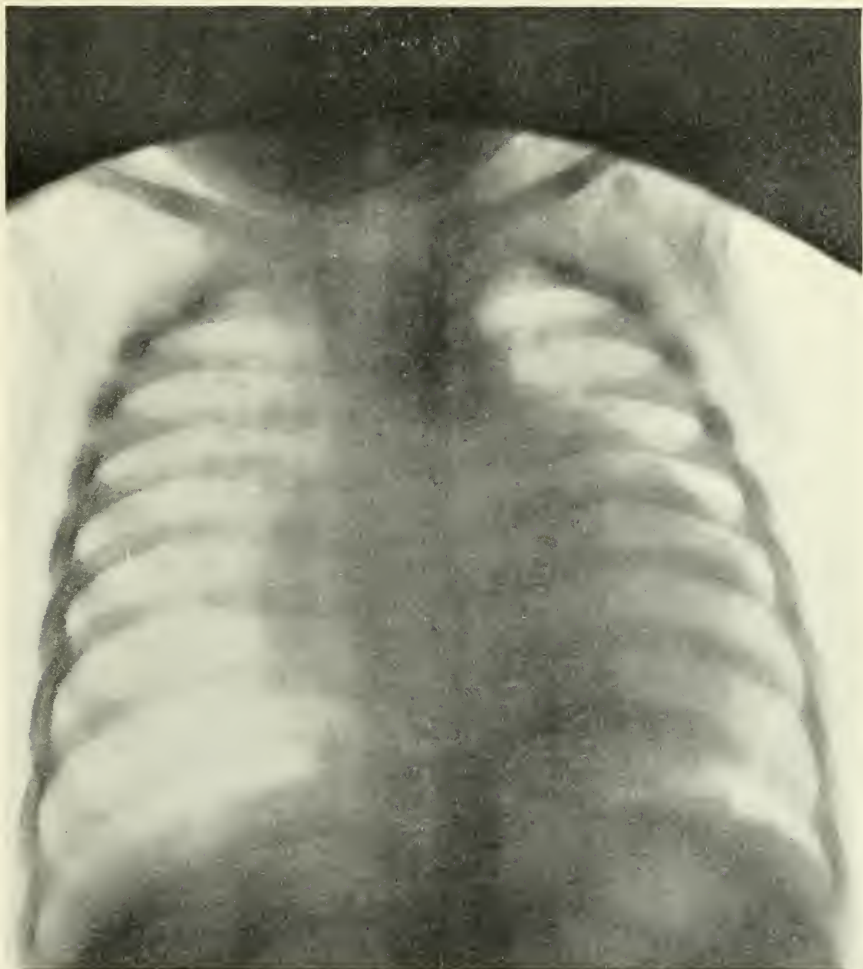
ROENTGENOGRAM OF CHEST OF G. S., TAKEN A FEW DAYS BEFORE DEATH.
